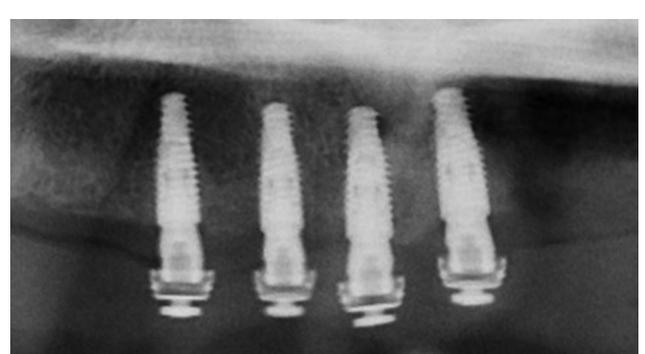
X-ray of implants after fixation of the retentions in the upper jaw.
